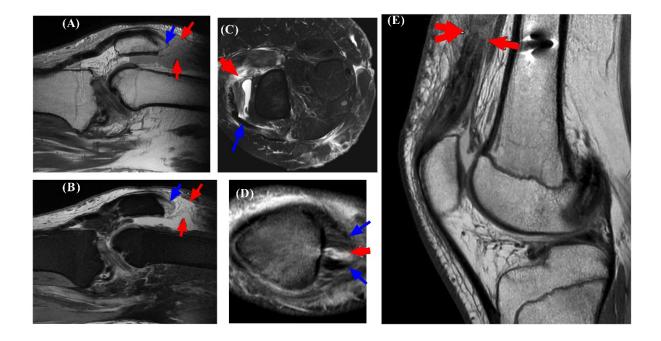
A case study of a 40-year-old male athlete with QT tear who was subjected to surgical treatment based on end-to-end tendinous repair showing medial-weighted MR image without fatsaturation in sections A & B with the rupture occurring at the myotendinous junction (red arrows). Section C shows a rupture of the right QT with the axial T2-weighted fat-saturated MR image showing total disruption of the vastus medialis tendon (red arrows) while the vastus lateralis remained intact (blue arrows). In section D, there is a partial rupture of the QT with the coronal medial-weighted fat-saturated MR image revealing a partial tear of the rectus femoris (red arrows) while the lateral and middle sections remain unaffected (blue arrows). Lastly, section E shows a male QT tear subjected to surgical end-to-end repair with the intermediate-weighted non-fat saturated MR image showing a complete rupture occurring at the myotendinous junction (red arrows)
